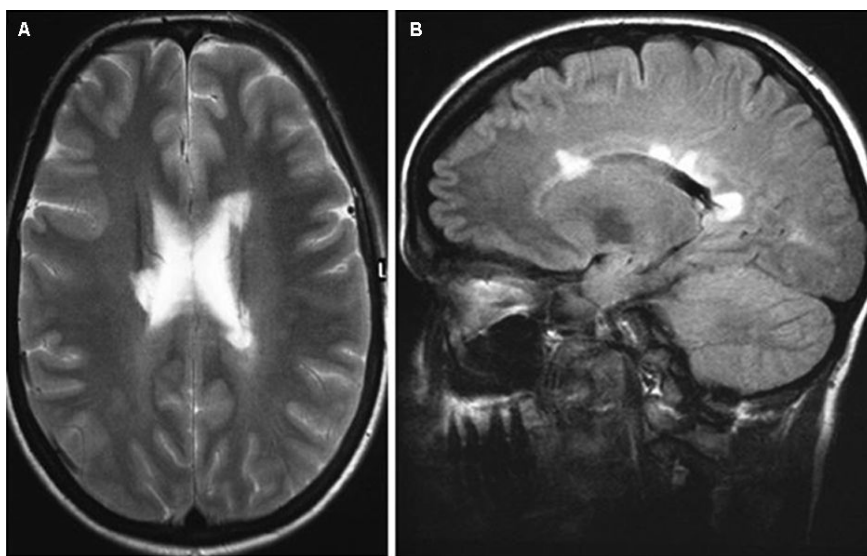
(A) Axial T2-weighted and (B) sagittal fluid-attenuated inversion recovery magnetic resonance imaging sequences show periventricular hyperintense lesions in a typical pattern for multiple sclerosis.
